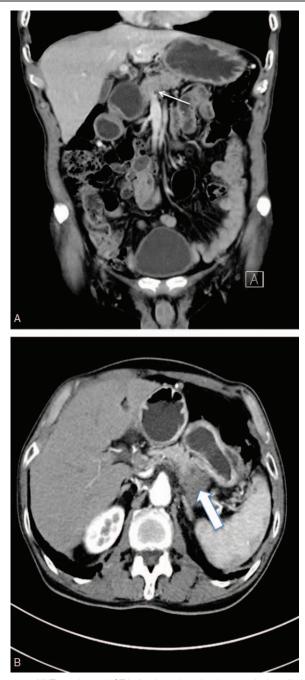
(A) The enhanced CT indicating a low-density mass in the tail of the pancreas (thick arrow). (B) The portal annular pancreas (thin arrow). CT = computed tomography.
